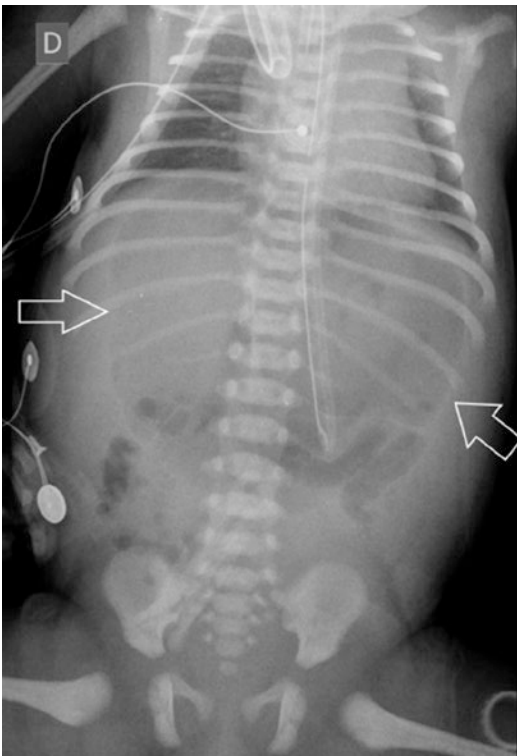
Spontaneous pneumoperitoneum in 34 weeks premature on its second day of life. Plain film of the abdomen. A large area of radiolucency (*arrows*) is visible superimposed to the upper abdomen. The origin of the perforation was not found at exploratory surgery. Follow-up was uneventful
